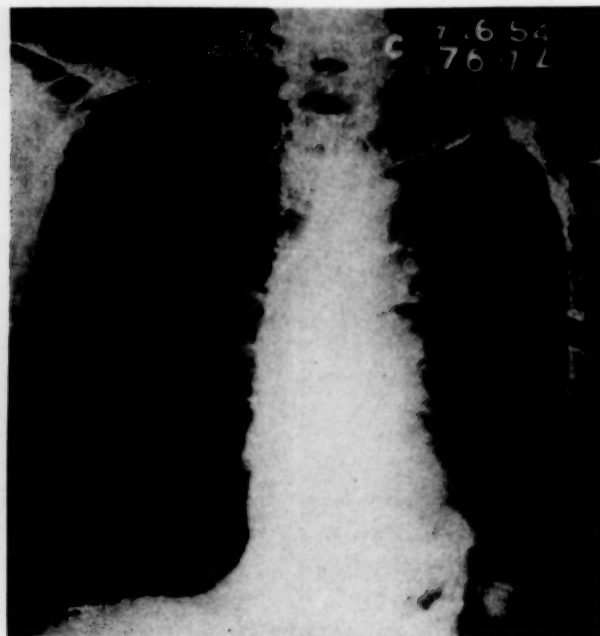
X-ray after 2,200 roentgens to the tumor, Case II.
